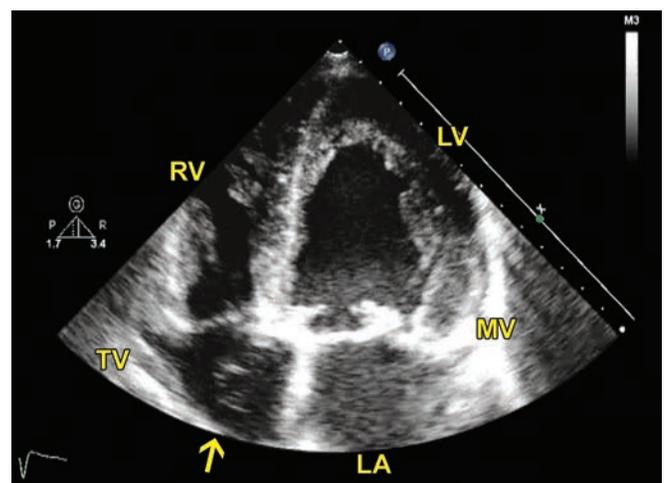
Apical 4 chamber zoomed.
